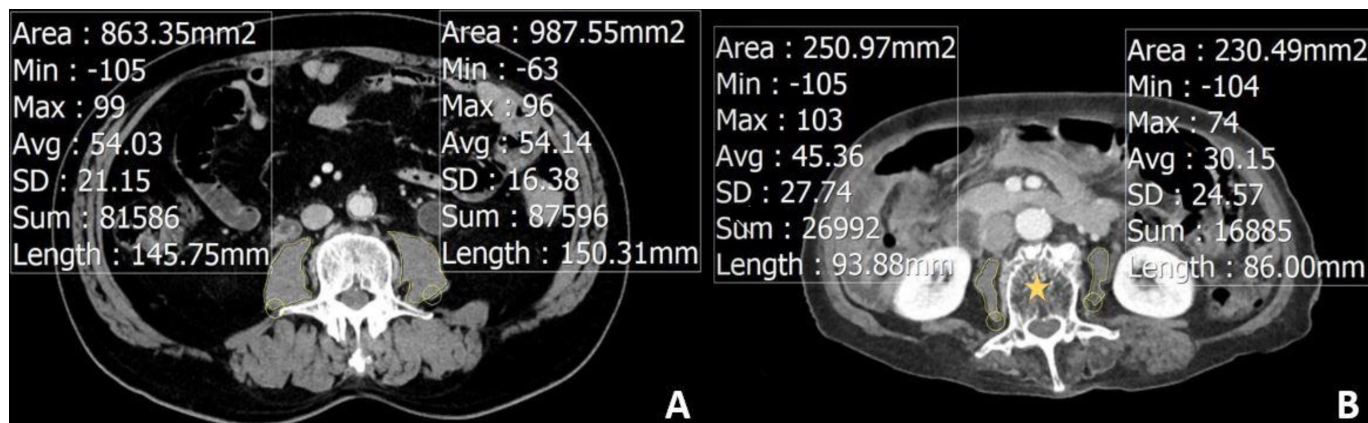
Axial abdominal and pelvic CT images outlining the psoas muscles bilaterally were obtained at L3 level in two different patients (yellow stars). (A) 69-year-old man, image presents a cross-sectional area (yellow outline) measuring left side and right side which were 987.55 mm² and 863.35 mm² and mean attenuation measuring left side and right side which were 54.14 HU (SD: 16.38) and 54.03 HU (SD: 21.15), respectively. (B) 77-year-old woman, image presents a cross-sectional area (yellow outline) measuring left side and right side which were 230.49 mm² and 250.97 mm² and mean attenuation measuring left side and right side which were 30.15 HU (SD: 24.57) and 45.36 HU (SD: 27.74), respectively.
